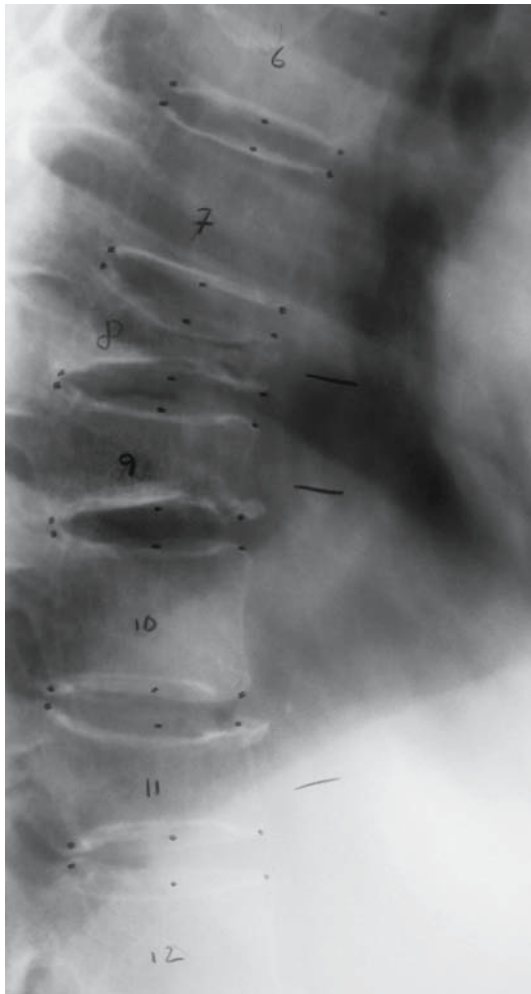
Lateral thoracic radiograph shows a grade 3 fracture T8 and grade 2 fractures of T9 and T11
